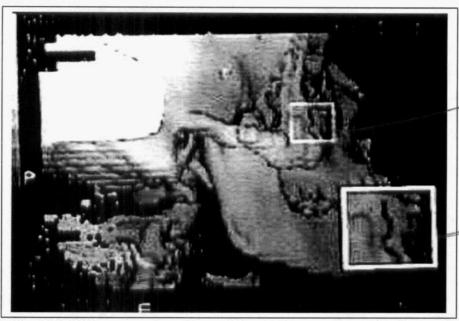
3-D CT reconstruction of facial bones in right lateral view
